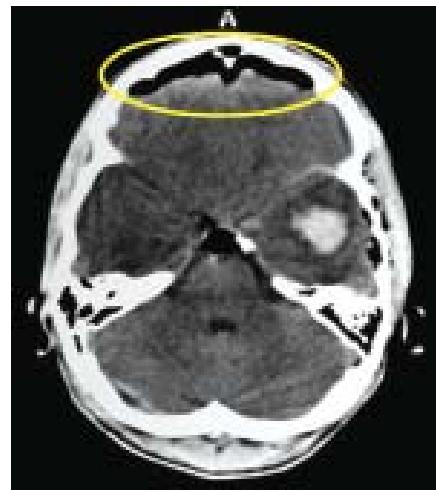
CT scan showing extra dural hematoma
